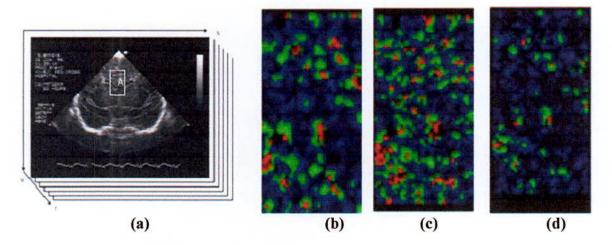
Estimation of optical flow velocity with different estimation methods of indicating block A. (a)Original ultrasonogram image sequence and optical flow images obtained by (b) Local Optimization (c) Global Optimization (d) Combined Local Global Optimization
